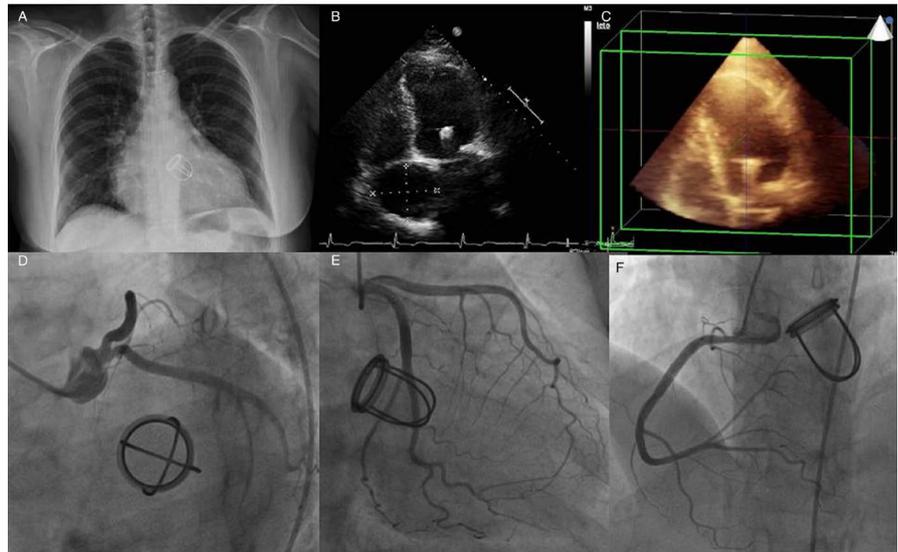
A- X-ray showing cardiomegaly and mitral Starr-Edwards prosthetic valve. B-2D and C-3D transthoracic echocardiogram in four chamber view with Starr-Edwards mitral prosthetic valve and bi-atrial enlargement. E, F, G- cardiac catheterization showing epicardial coronary arteries without obstructions and Starr-Edwards mitral prosthetic valve.
